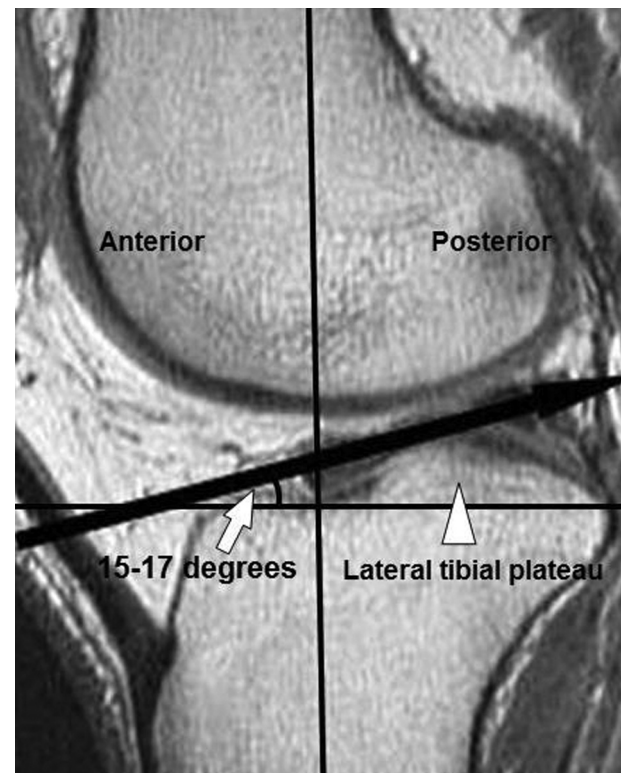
Magnetic resonance imaging of the right knee shows that tibial slope measurement is ranged from approximately 15° to 17° (white arrow) on the lateral side. The white arrow indicates the lateral tibial plateau.
